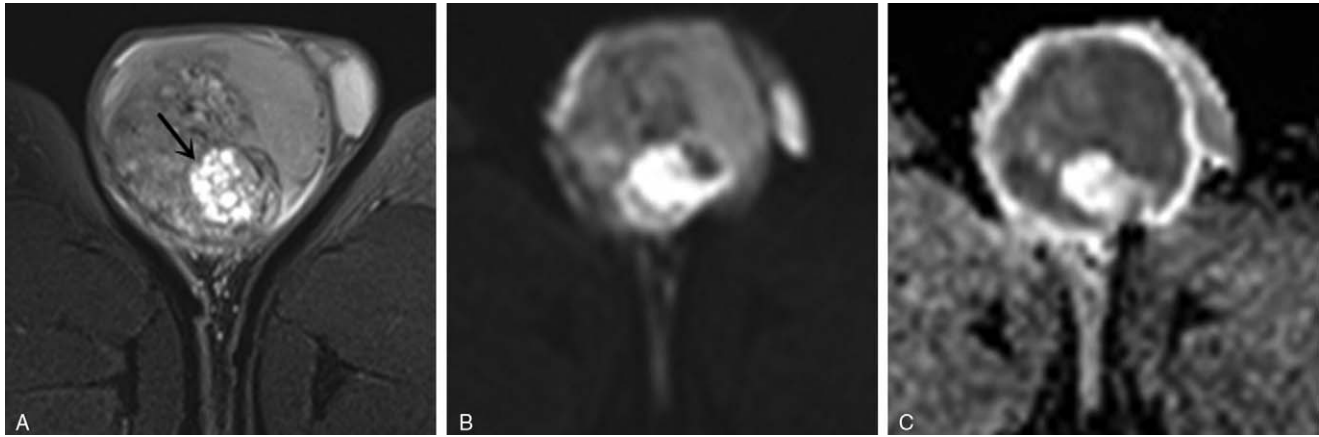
Images of a 41-year-old man with NSGCT in right testis. (A) Axial fat-suppressed T2-weighted image shows a hyperintense multinodular tumor with focal necrosis (arrow). (B) Axial DWI presents with heterogenous hyperintense signal with a mean ADC value of $0.83 \times 10^{-3} \text{ mm}^2/\text{s}$ (C). ADC = apparent diffusion coefficient.
